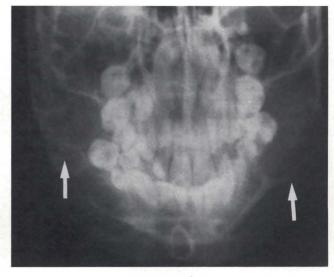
Posterior-anterior mandibular radiograph of the twelve-year-old patient, demonstrating bilateral expansion and thinning of the cortical plates.
